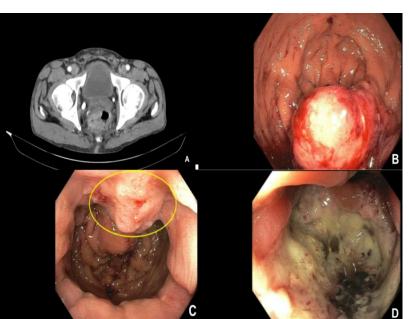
CT A/P (A) revealing an irregular, asymmetric rectal wall thickening centered laterally on the left, highly concerning for rectal carcinoma, in addition to a focal left-sided outpouching from the rectum, suggesting a thick-walled diverticulum.
